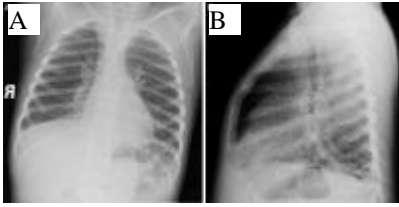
(A) Anteroposterior radiograph from a child with presumptive viral pneumonia. (B) Lateral radiograph of the same child with presumptive viral pneumonia
